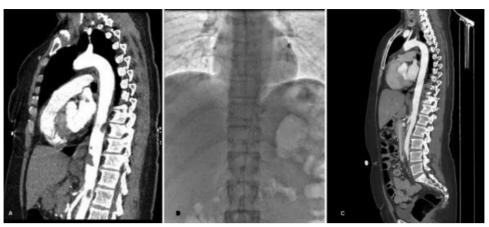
(A) Preoperative sagittal view of computed tomography angiography demonstrating multiple thrombi in the thoracic aorta. (B) Control angiogram of the thoracic aorta showing physician-modified catheter placement. (C) Control computed tomography angiography of the patient at the two-month follow-up.
